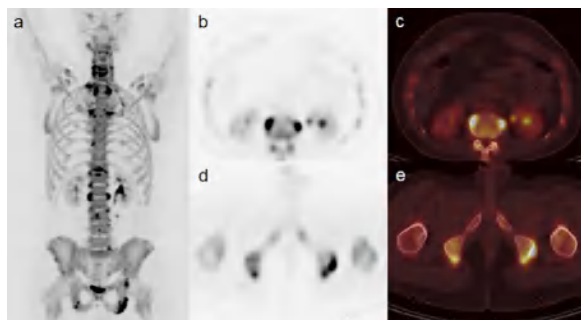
$^{18}\text{F}$ -NaF positron emission tomography image of a 33-year-old patient who was diagnosed with ankylosing spondylitis according to the Assessment of SpondyloArthritis International Society criteria. The maximum intensity projection image (a) reveals several positive findings including syndesmophytes of T-, L- spines, particularly at L1 with a maximum standardized uptake value (SUVmax) of 8.76 (b, c), and enthesopathies of the bilateral ischial tuberosity (right SUVmax=6.37 and left SUVmax=7.02; d, e).
